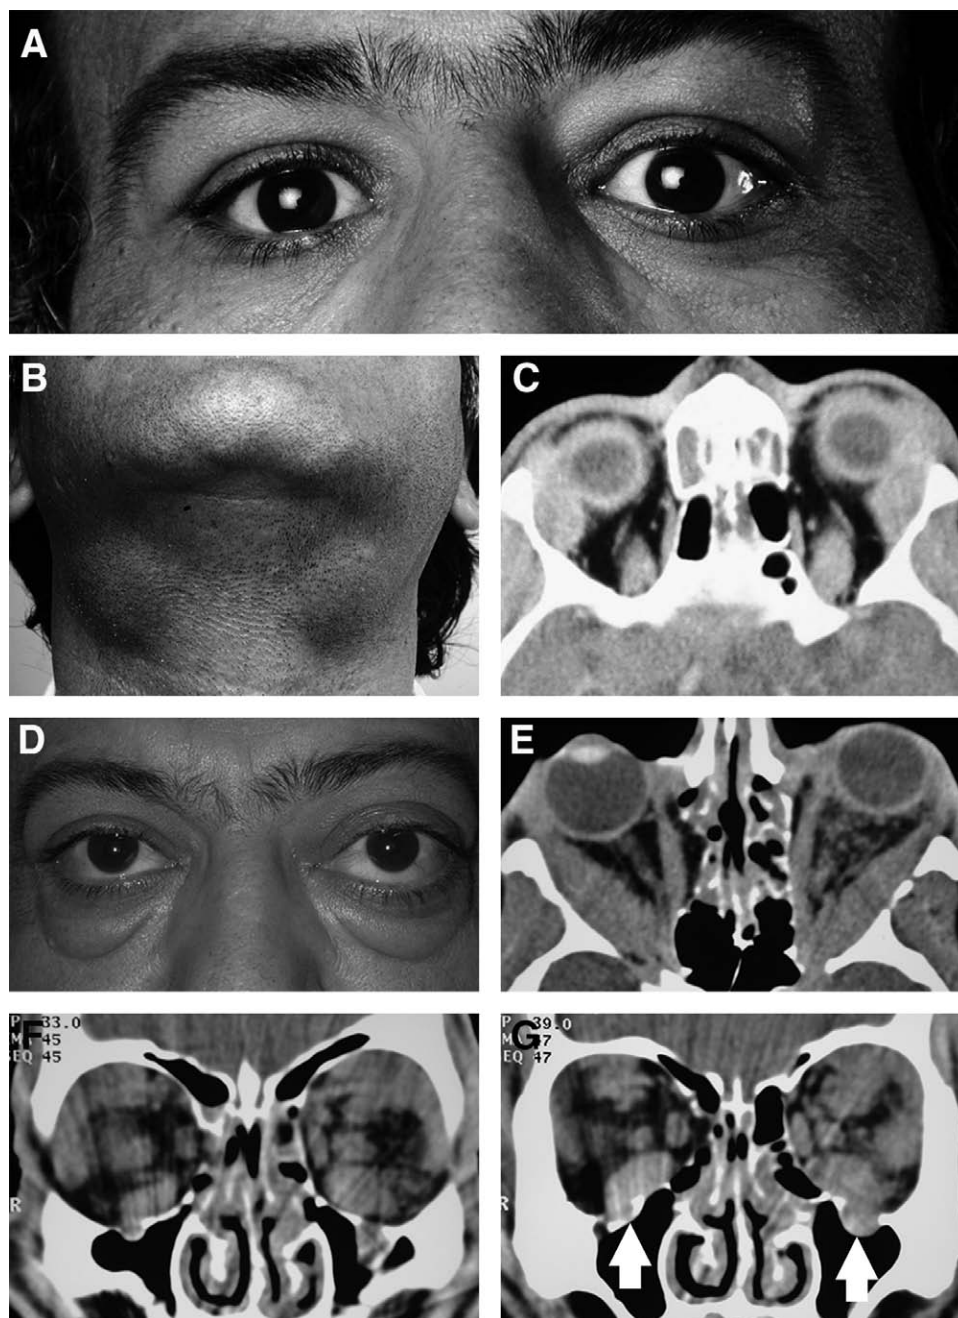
Case 5. Initial presentation with “Mickulicz disease” pattern and evolved into extraocular muscle disease, enlarged infraorbital nerves, sinus disease. A and B, A 37-year-old man presented in 1991 with bilateral lacrimal and submandibular gland enlargement. C, An axial CT scan showed the enlarged lacrimal glands which on biopsy were reported to show reactive lymphoid hyperplasia. He responded to a short course of oral steroids and was lost to follow up. D, He returned in 2001 with 2 to 3 years increasing bilateral proptosis and eyelid swelling. E, F, and G, CT scans now showed enlarged extraocular muscles, disease in the lacrimal glands and superior orbits, and definite enlargement of the infraorbital nerves and canals (arrows). Biopsies from the orbit showed reactive lymphoid hyperplasia again. He responded to oral steroids, but moved overseas and was again lost to follow up. These biopsies were reviewed in 2007 and he had IgG4+ plasma cells of 150 per hpf and an IgG4+/IgG+ plasma cell ratio of 300%.
